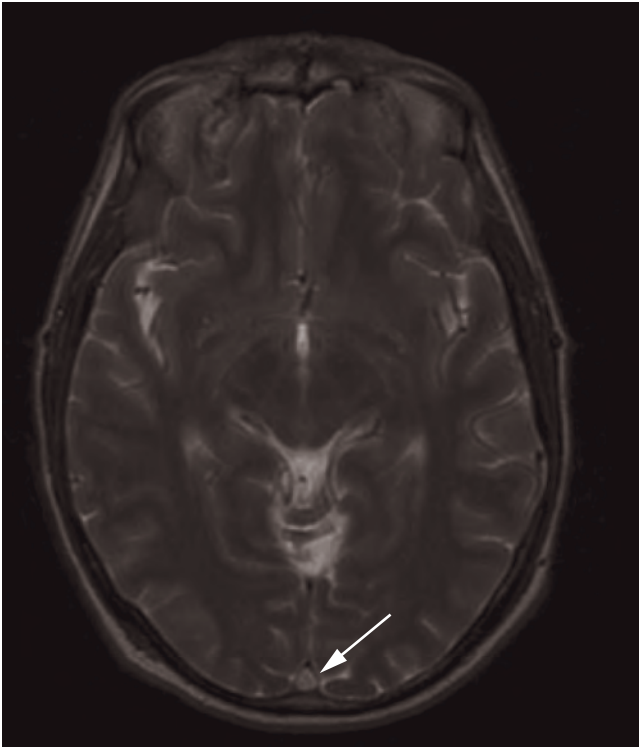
Absence of flow in the superior sagittal sinus caused by thrombus (MRI T2W). Arrow indicates thrombosed sagittal sinus.
